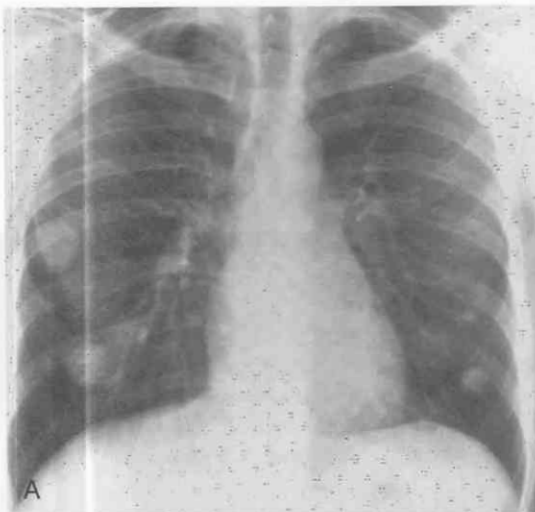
Disseminated cryptococcal infection. Chest film (A) and CT (B, C) show multiple pulmonary nodules.
